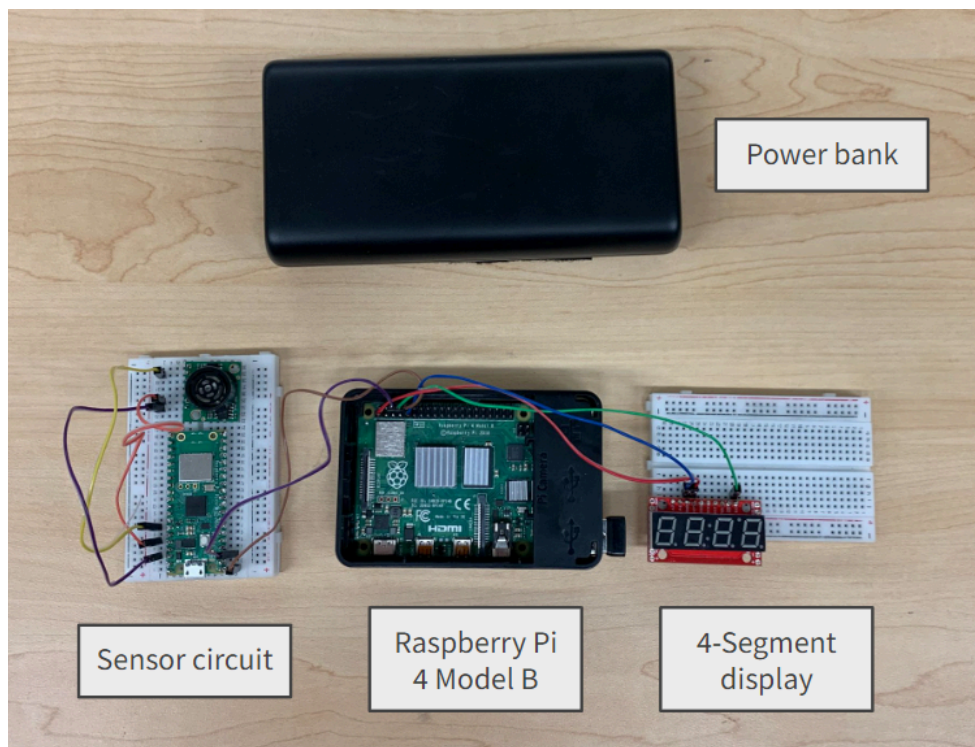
The functional prototype of the measuring and displaying features of the prototype. Parts include: the Raspberry Pi 4 Model B, Raspberry Pi Pico W, SparkFun 7 Segment Serial Display, and an ultrasonic sensor.
